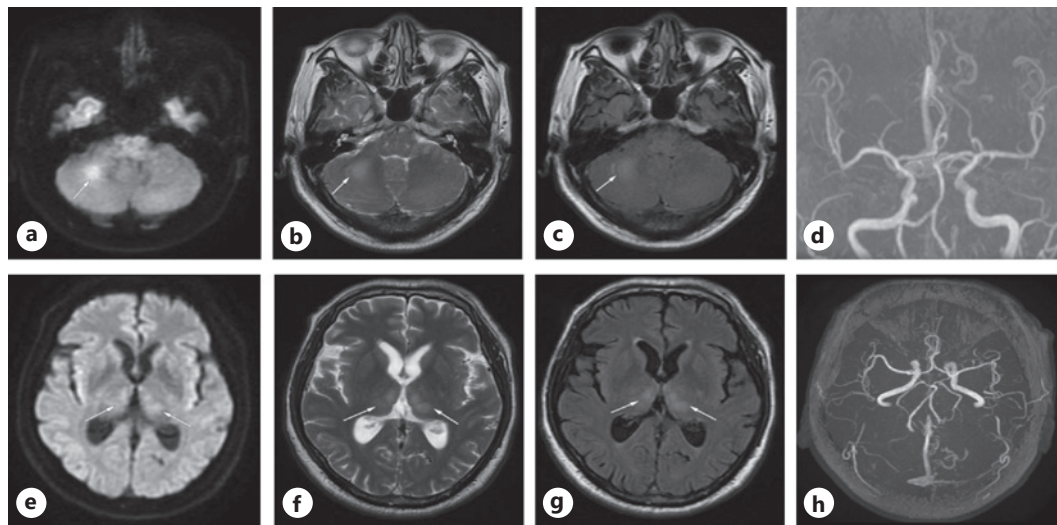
Baseline MRI of the brain. a–c The right cerebellar pontine arm shows a slightly increased DWI signal and a slightly high signal on T2WI and T2 FLAIR; e–g Bilateral thalamus with multiple patchy abnormal signal shadow, slightly high signal on DWI, and slightly high signal on T2WI and T2 FLAIR; d, h No significant abnormalities in head MRA. DWI, diffusion weighted imaging.
